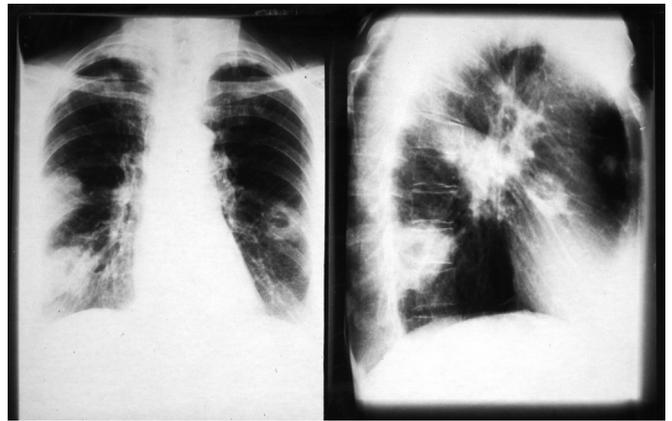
Patterns of generalization: Vasculitis affecting multiple organs, and evolution of new granulomas. After an initial phase with granulomatous inflammation limited to the upper respiratory tract of one year duration, the patient was found to have generalized WG with rheumatic complaints, (biopsy-proven) focal and segmental necrotizing glomerulonephritis, polyneuropathy and c-ANCA/PR3-ANCA. Remission was induced with cyclophosphamide and corticosteroids. Thereafter, the patient experienced two major relapses with night sweats, weight loss, new erythrocyturia without an increase of serum creatinine and a rise in the c-ANCA titer. Both relapses were characterized by an acute flare of multiple, newly developed biopsy-proven granulomas. Multiple nodules with a tendency to cavitate are seen on the patient's thorax X-ray.
